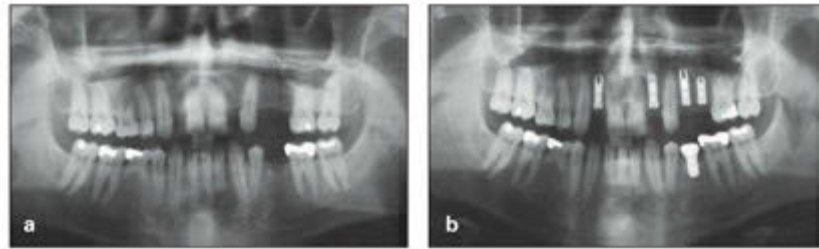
(a) Pretreatment panoramic radiograph of a 23-year-old man, revealing missing teeth, diastemata, and tooth displacement. (b) Panoramic radiograph after alignment, space distribution, and placement of several single-tooth implants.
